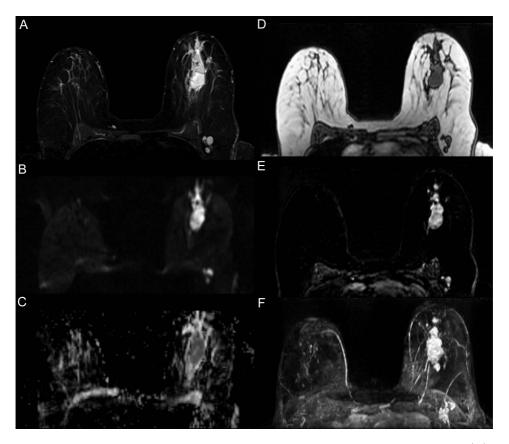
MR images from a breast cancer patient, a T_2 -weighted image (A), diffusion weighted image (B) and an ADC-map calculated from the diffusion-weighted images (C). On the right side, a T_1 -weighted image (D), a subtraction image after contrast agent injection (E), and a projection of the maximum signal intensity of the subtraction image volume (F).
